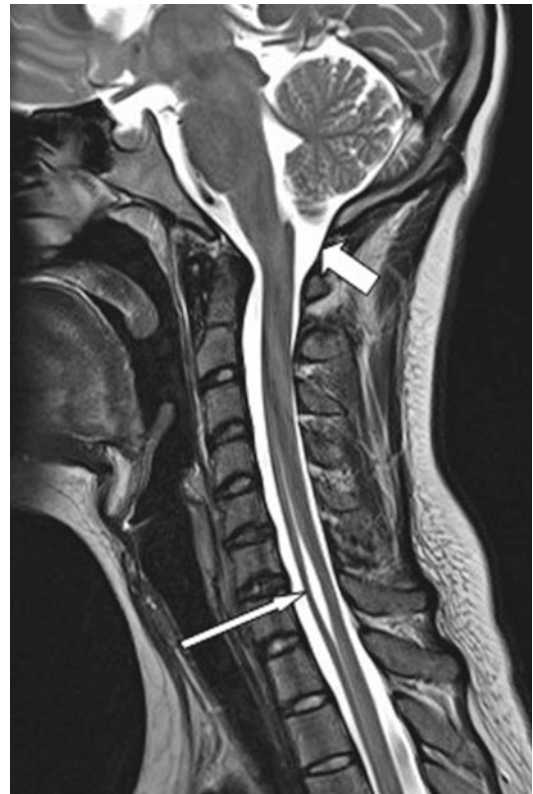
MR image of a “cleft” or “spindle”. This T2-weighted midline sagittal MRI of the cervical spine shows a typical cleft (*long arrow*) behind the body of C7. The craniocervical junction is normal (*short arrow*)
